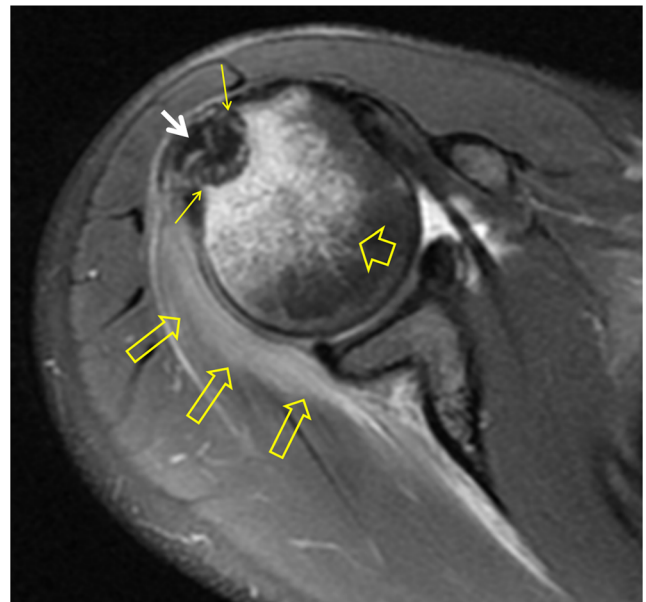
A 35-year-old female patient with a 6-month history of pain. The fat-suppressed axial PD-weighted MRI shows the anterior calcific deposit of the infraspinatus (*arrow*), extending into the bone (*long arrows*) with reactive subcortical bone marrow oedema (*short open arrow*). Reactive oedema into the infraspinatus muscle is also shown (*long open arrows*)
